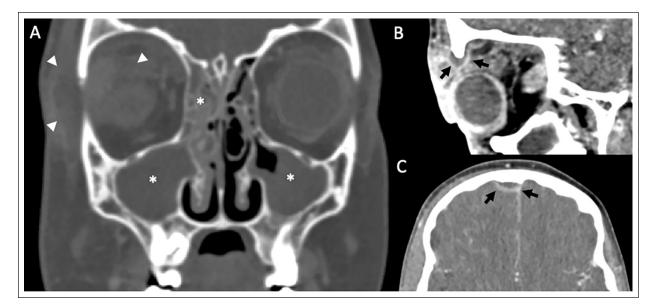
Contrast-enhanced CT of the paranasal sinuses and orbits. The coronal reformat (A) demonstrates widespread mucosal thickening and secretions predominantly affecting the maxillary antra and right ethmoid labyrinth (asterisks). Intraorbital and periorbital soft tissue stranding is also present (arrowheads). An oblique sagittal reformat through the right orbit (B) demonstrates a subperiosteal abscess extending into the orbit beneath the superior orbital rim. An axial section through the anterior cranial fossa (C) shows a peripherally enhancing extradural collection associated with the superior sagittal sinus.
